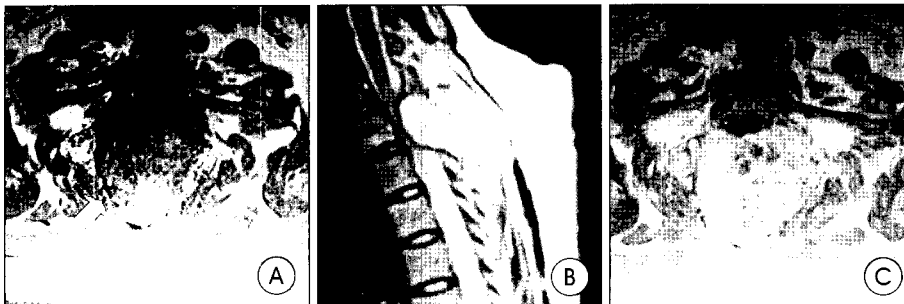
Axial magnetic resonance of T1 weighted image (A) of the second thoracic vertebra reveals a well-defined expansile mass lesion of posterior elements, and a hypo-signal intense rim is seen at the interface between the mass and surrounding normal tissue (arrow). Sagittal T2 weighted image (B) shows increased signal intensity in the mass with multiple internal septations, and the spinal cord is compressed from behind. Axial gadolinium-enhanced T1-weighted axial image demonstrates a heterogenous enhancement of the mass (C).
